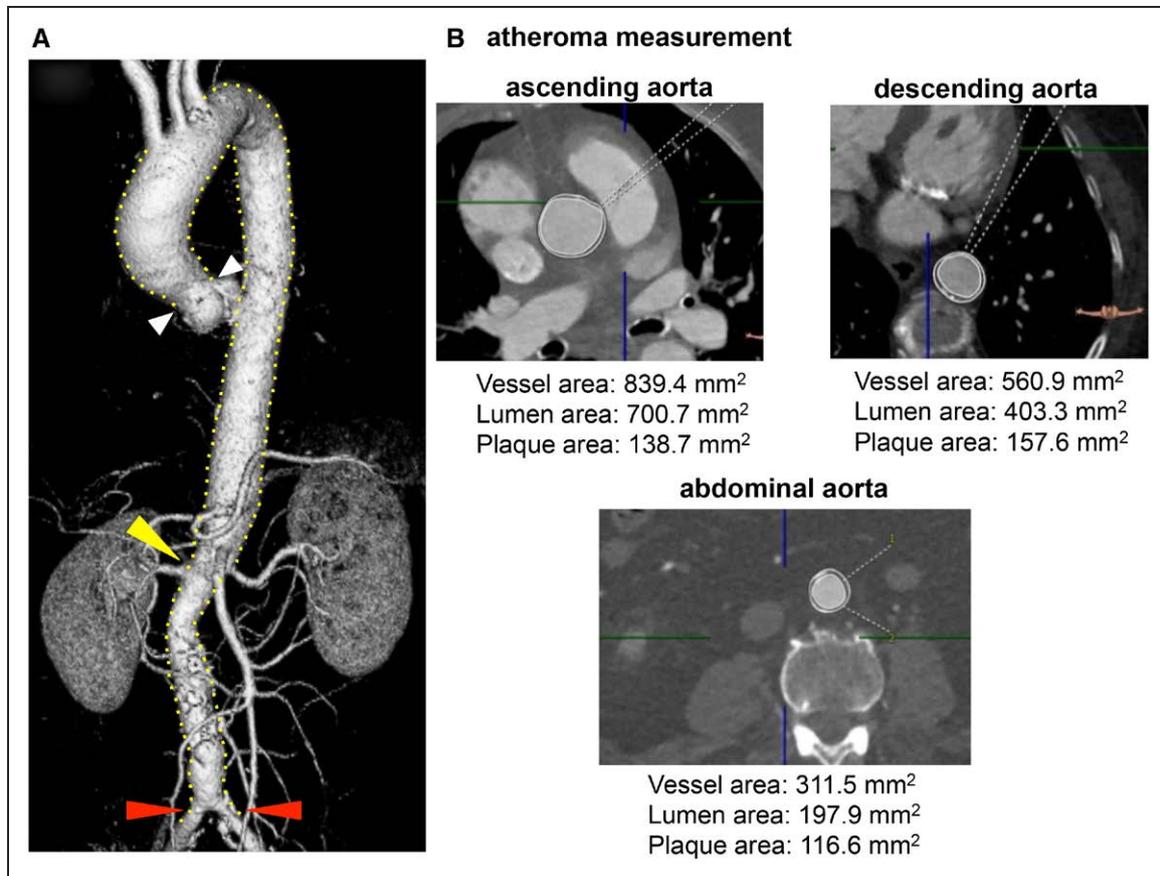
Quantitative measurements of aorta atheroma volume on multislice computed tomography.
